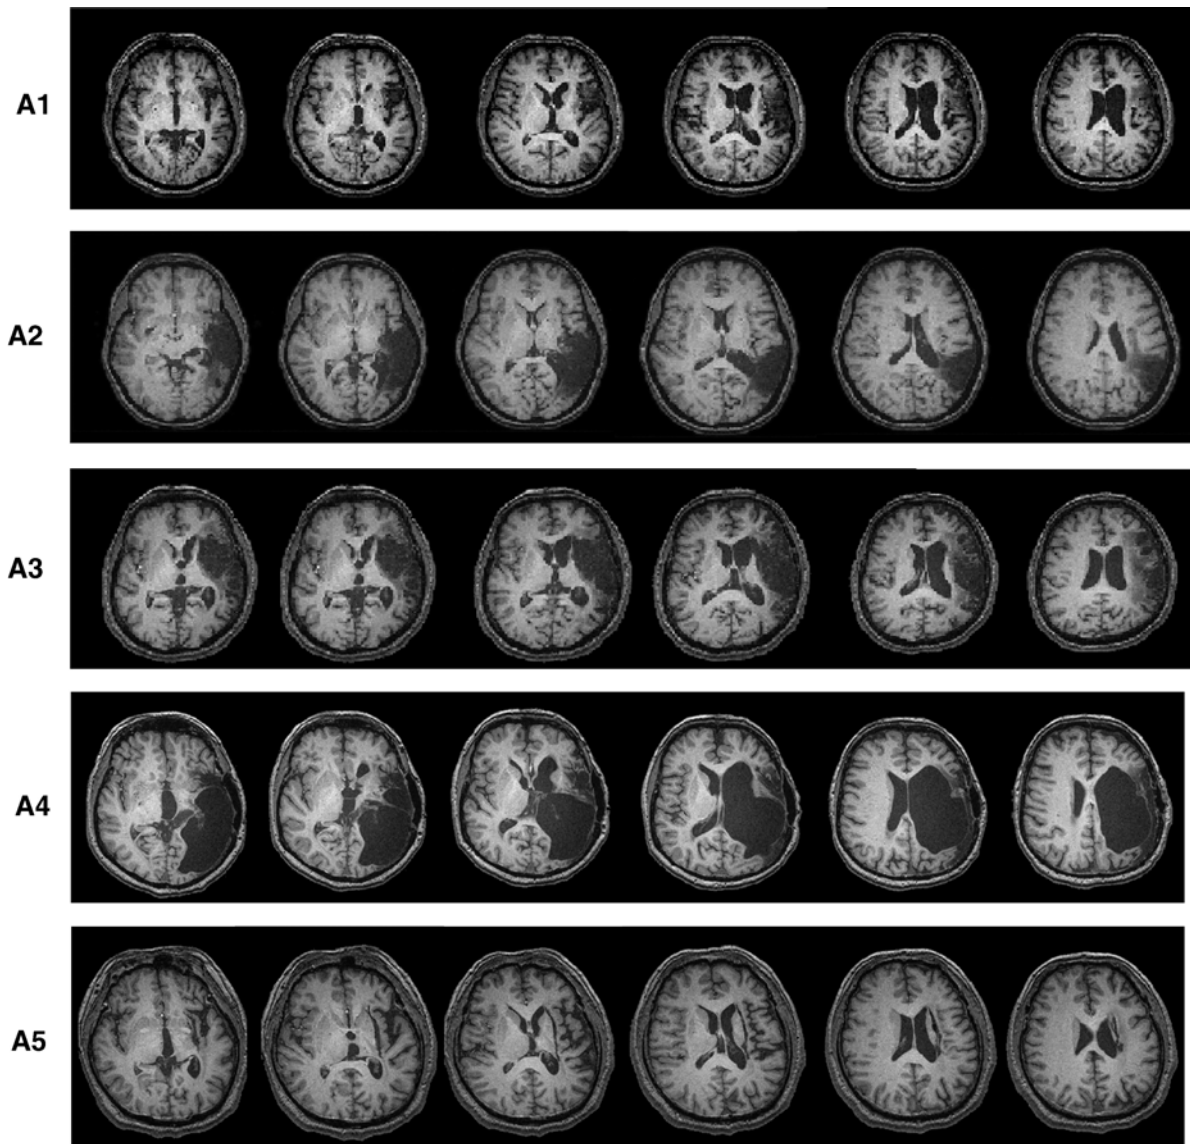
Axial anatomical T1 MRI scans from selected perisylvian slices in five patients who participated in the study. See text for details regarding lesion boundaries.
